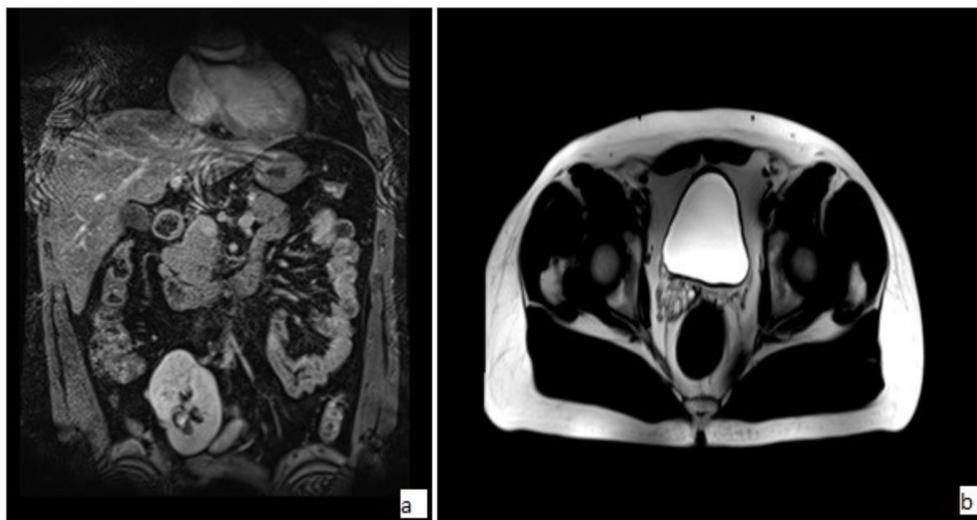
a. Ectopic left kidney in magnetic resonance imaging, b. Left seminal vesicle agenesis in magnetic resonance imaging
